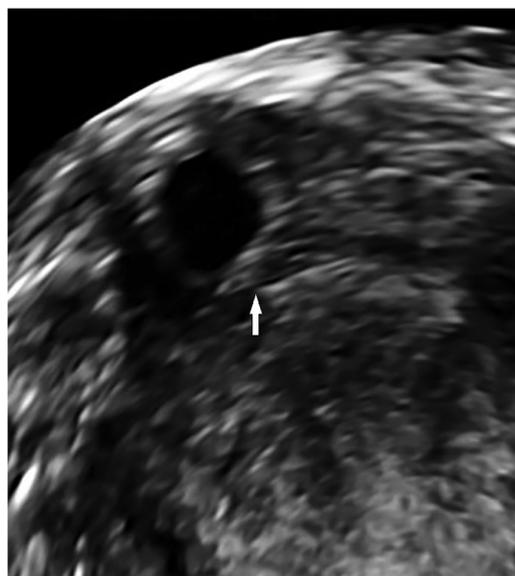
Three-dimensional ultrasound imaging demonstrating the proximal interstitial segment of the tube (arrow) joining the uterine cavity to the ectopic pregnancy, described as an 'interstitial line sign'.
